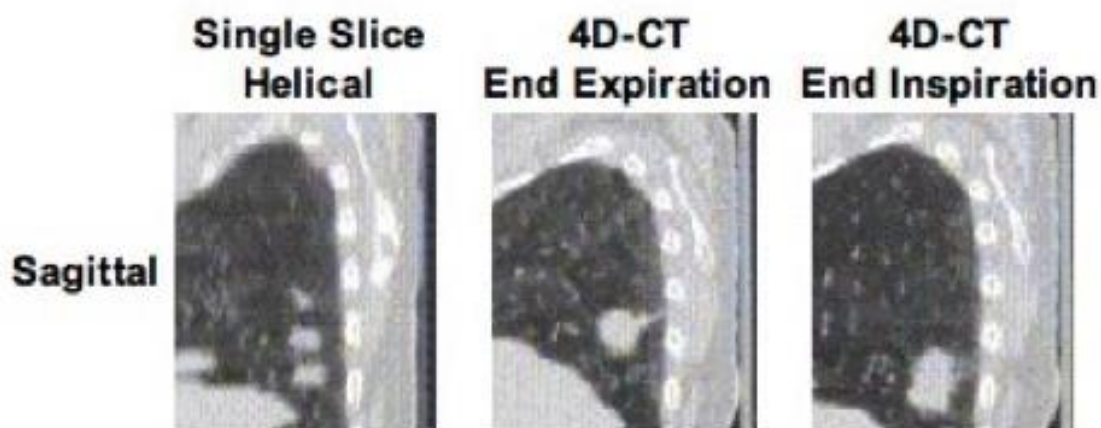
on the left, a single slice 3D-CT sagittal image of a lung cancer patient. Tumour motion produces an image artifact where three artificial small tumour volumes appear to be present in the lung. On the right, two 4D-CT images (sampled at maximum exhale and inhale) show there is actually one tumour volume moving along the superior-inferior axis of the lung.
